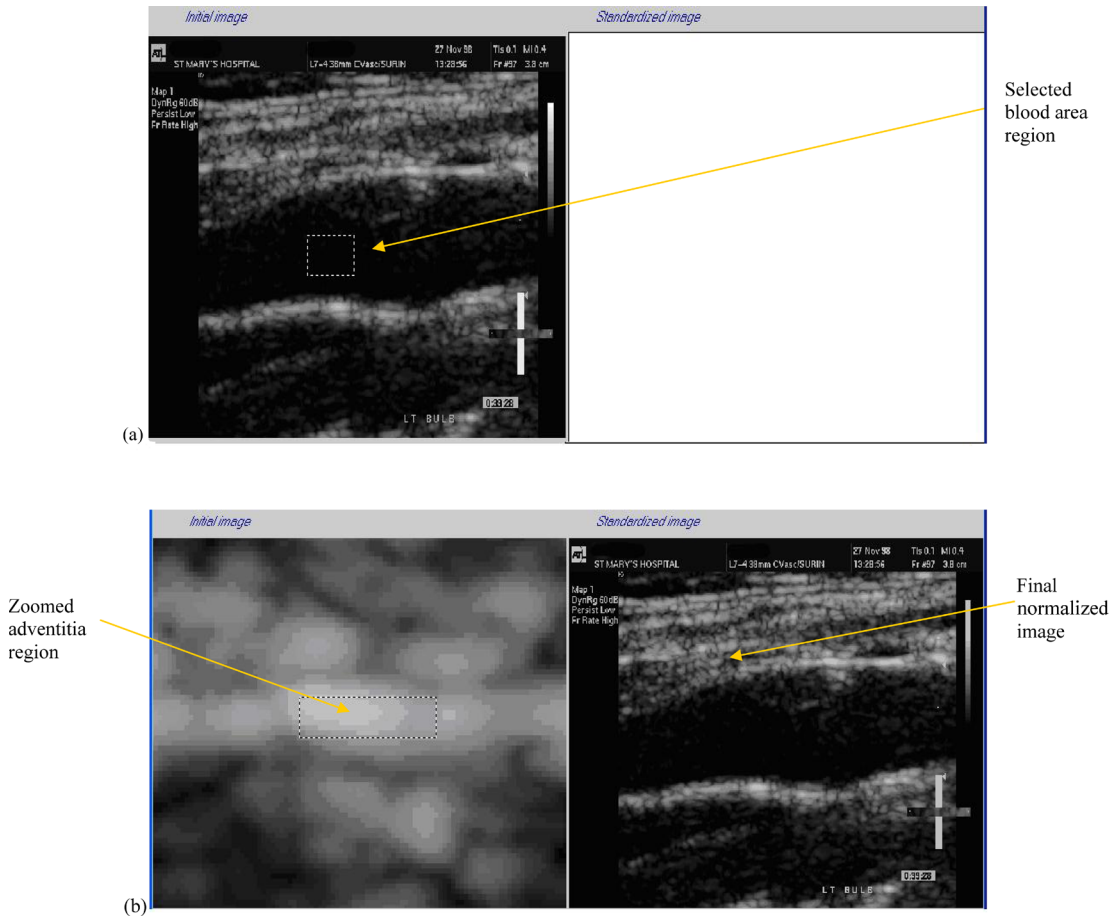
Normalization of a carotid ultrasound image. Two reference points are selected to normalize the image: (a) blood area and (b) adventitia area.
